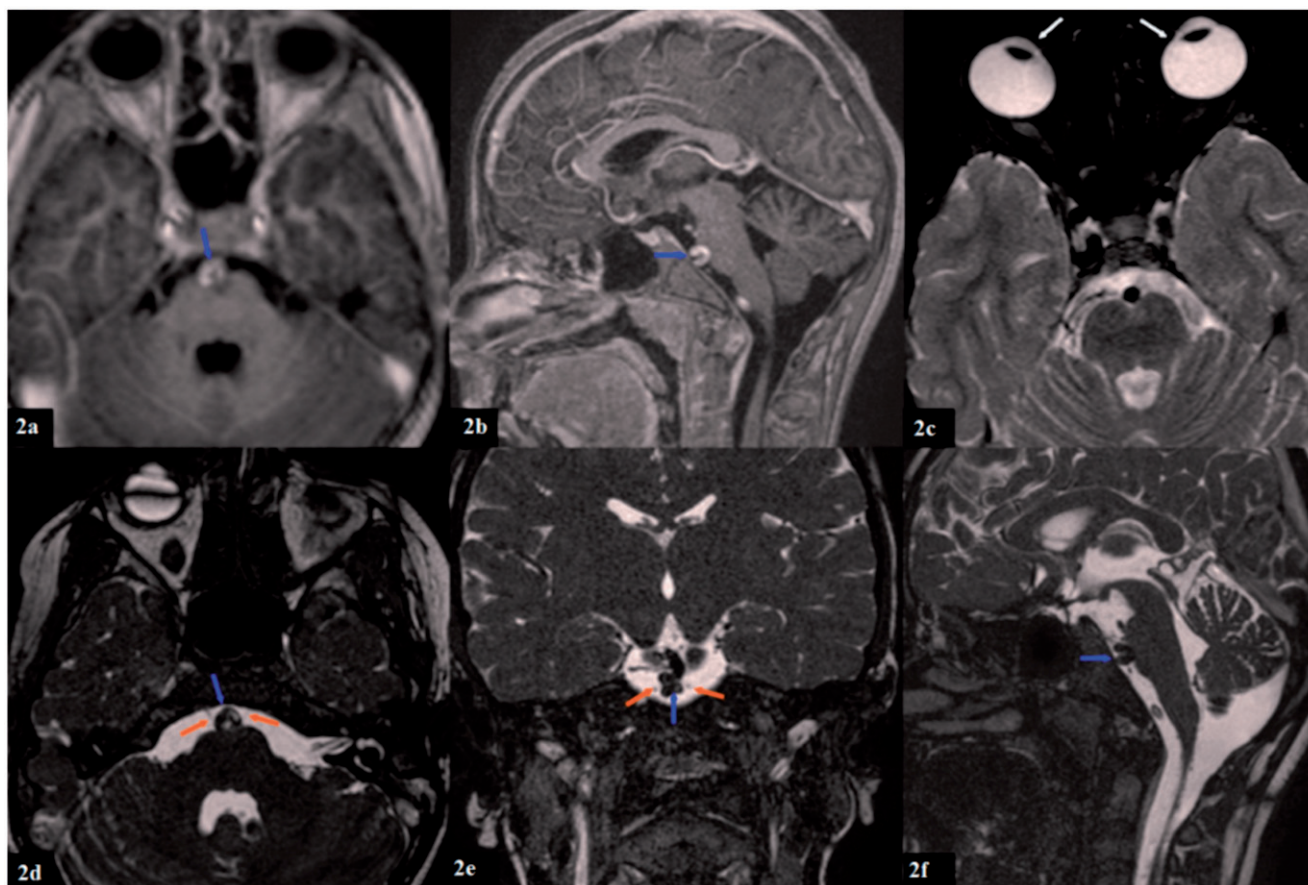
(a–f) A contrast-enhanced axial and sagittal T1-weighted MRI shows the ectatic basilar artery (blue arrows) (a–b); an axial T2-weighted MRI shows medial deviation of the bilateral ocular globe secondary to bilateral sixth-nerve palsy (white arrows) (c); axial and coronal 3D-CISS MRI images reveal the localized ectatic basilar artery (blue arrows) in between the sixth nerves (orange arrows) and compressing them (d–e); a sagittal 3D-CISS image shows the pons compressing the ectatic basilar artery (blue arrow) (f).
